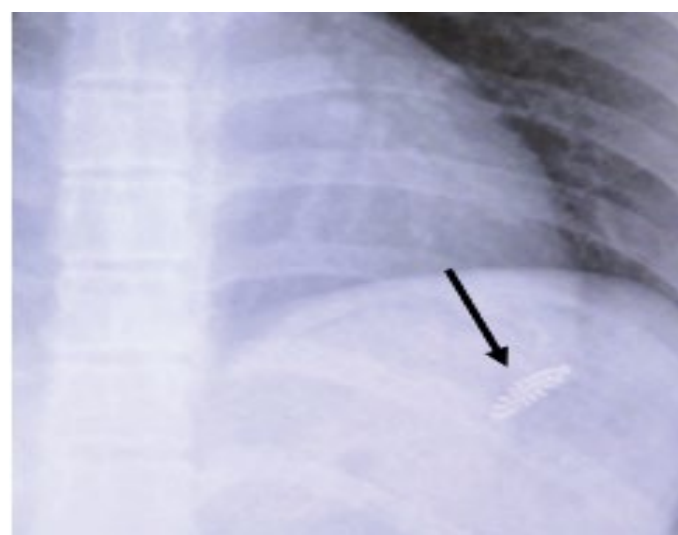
Thoracoabdominal X-ray suggesting the presence of gastric foreign body, toothbrush with radiopaque bristles.
